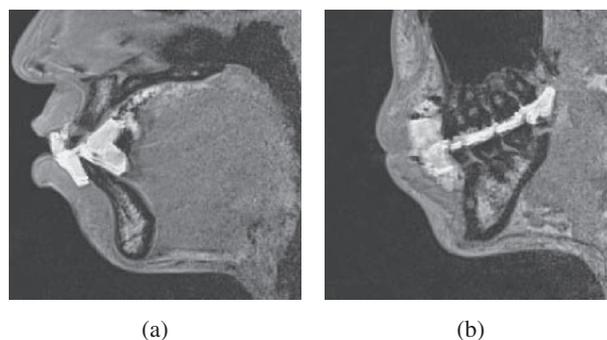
Anterior-to-posterior MR images after correcting the downward chemical shift artifact by shifting the dental mouthpiece region 1 pixel upward. The shifted images of the dental mouthpiece are overlapped with the original ones. The original images of (a) and (b) are shown in Figs. 3(a) and 3(b), respectively.
